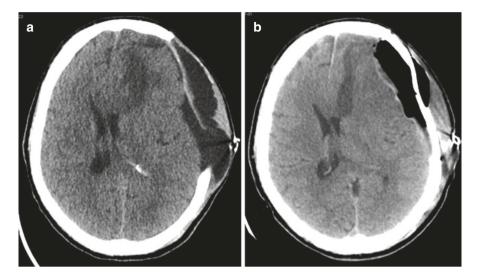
Noncontrast CT head of a severe traumatic brain injury patient before (a) and after (b) cranioplasty using an autologous graft 3 weeks after a small decompressive craniectomy
